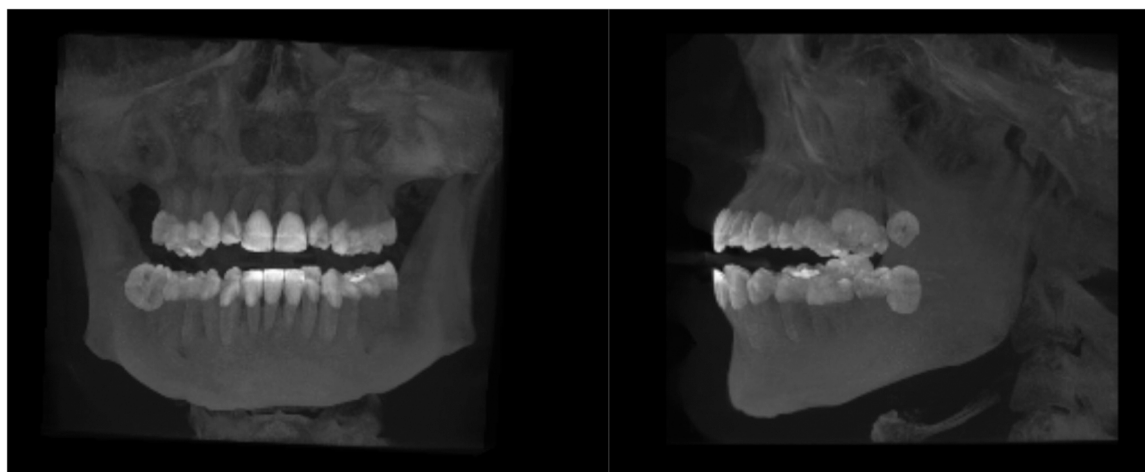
Three-dimensional reconstruction in cone beam computed tomography (CBCT) for detection of fenestrations (arrow: fenestration).
